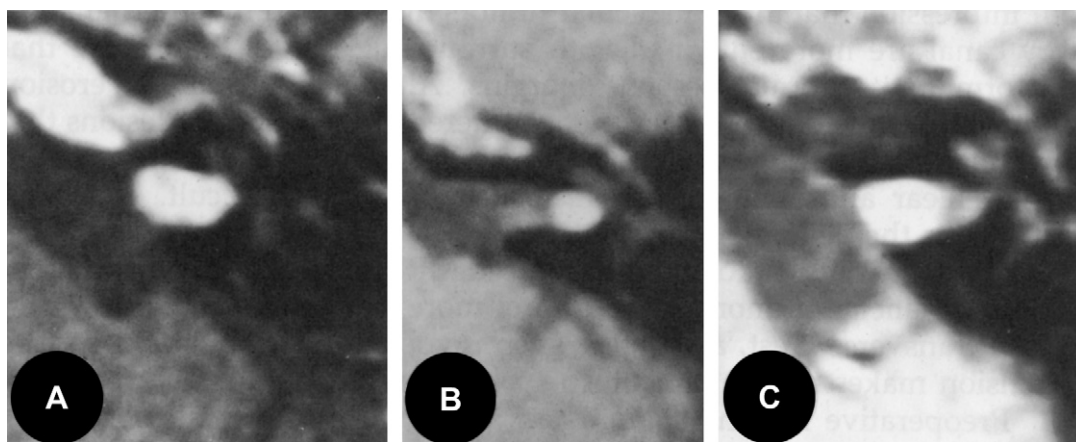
Intracanalicular acoustic neuromas on gadolinium-enhanced magnetic resonance imaging scans in the axial plane. Examples include a tumor involving the entire internal auditory canal (A), only the lateral extremity (B), and only the proximal portion adjacent to the porus acusticus (C). The management implications of these lesions are addressed in the text.
